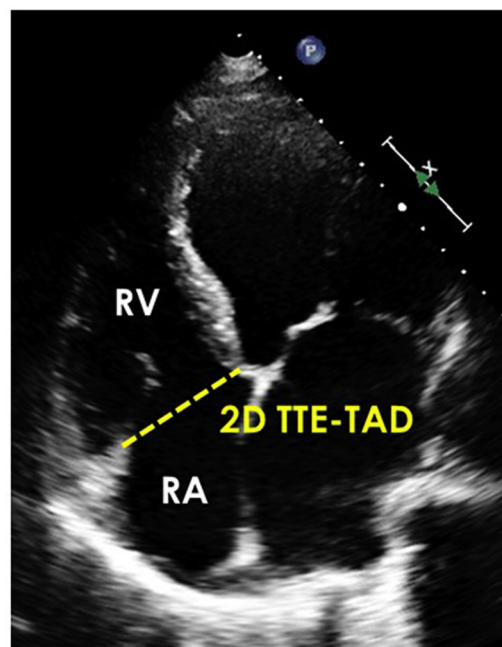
Measurements of 2D TTE-TAD were performed in the apical four-chamber view in mid-diastole at the time of the maximum TV opening between the two hinge points at the junction between the leaflets and the annulus (yellow dotted line). RA, Right atrium.
